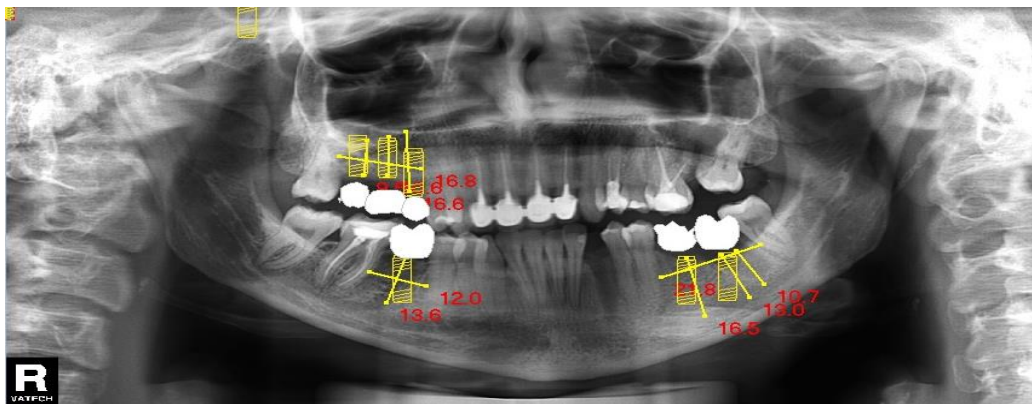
Orthopantomography-2D Analysis of the pre-implant space in all four quadrants
